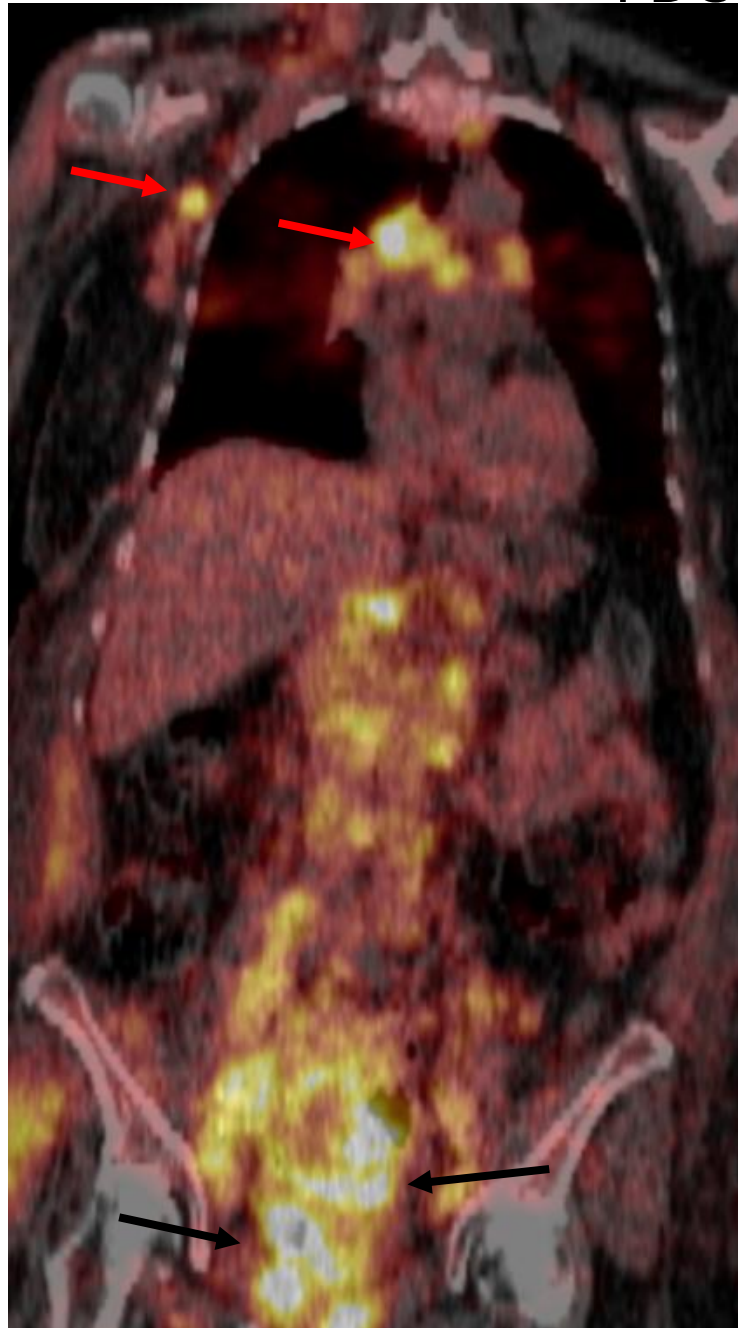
FIGO IVB staging parameters assessable by CT or PET-CT
